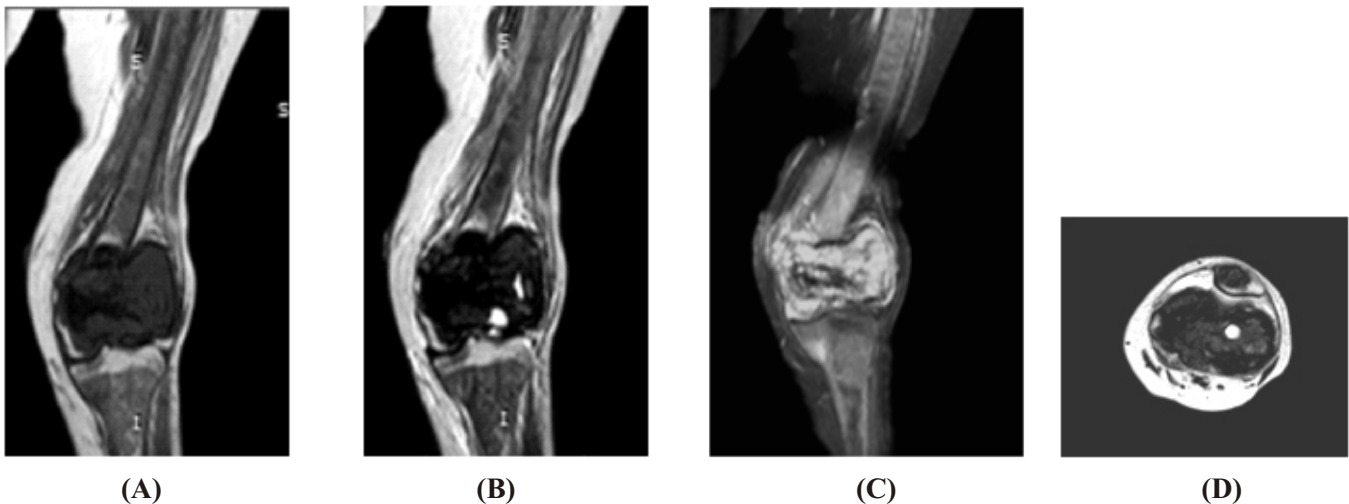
T1 W coronal (A), T2 W coronal (B), Contrast coronal (C), and T2W axial (D) MRI knee reveals T1 and T2 hypointense lesion in left femoral epi-metaphyseal location reaching upto articular surface with few cystic areas. Diffuse marrow alteration is seen in visualised bones. Other similar appearing lesions are seen in patella and femoral diaphysis.
